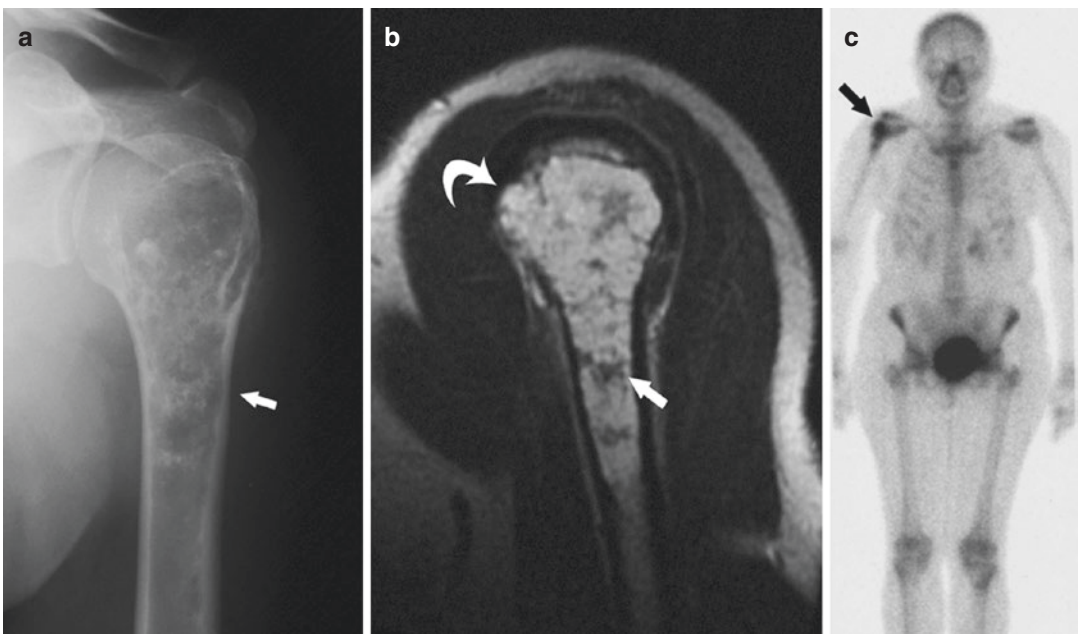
Chondrosarcoma: 38-year-old female with shoulder pain after heavy lifting at work. Radiograph (a) demonstrates a proximal humeral lesion with classic chondroid matrix. The lesion shows greater than two-thirds endosteal scalloping (arrow). (b) Coronal T2-weighted sequence
